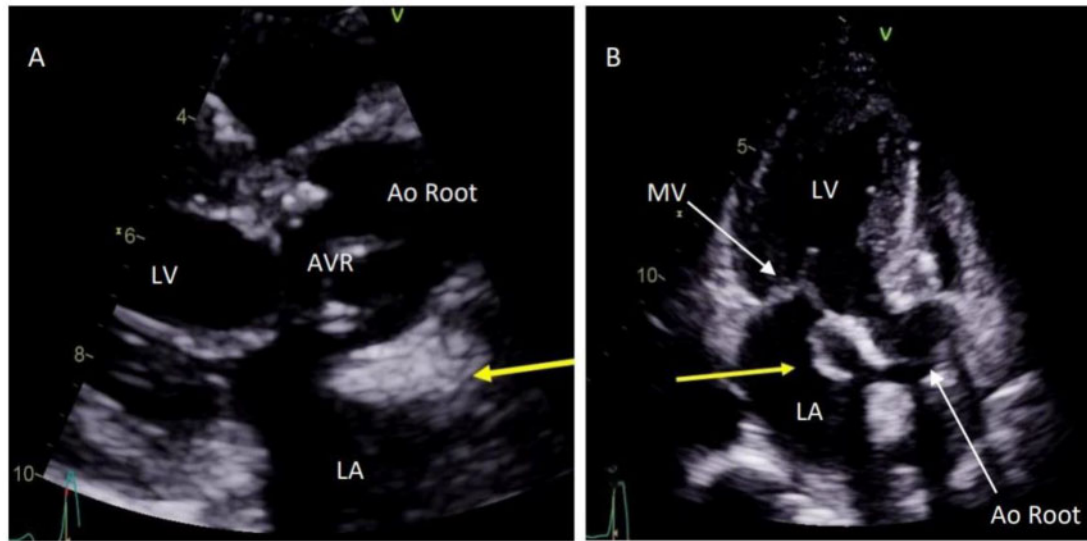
Pre-operative transthoracic echocardiogram of mycotic/pseudo-aneurysm. (A) Parasternal long axis. (B) Apical three chamber. Yellow arrow pointing to mobile echo density suggestive of mycotic pseudo-aneurysm. Ao Root, aortic root; AVR, aortic valve replacement; LA, left atrium; LV, left ventricle; MV, mitral valve.
